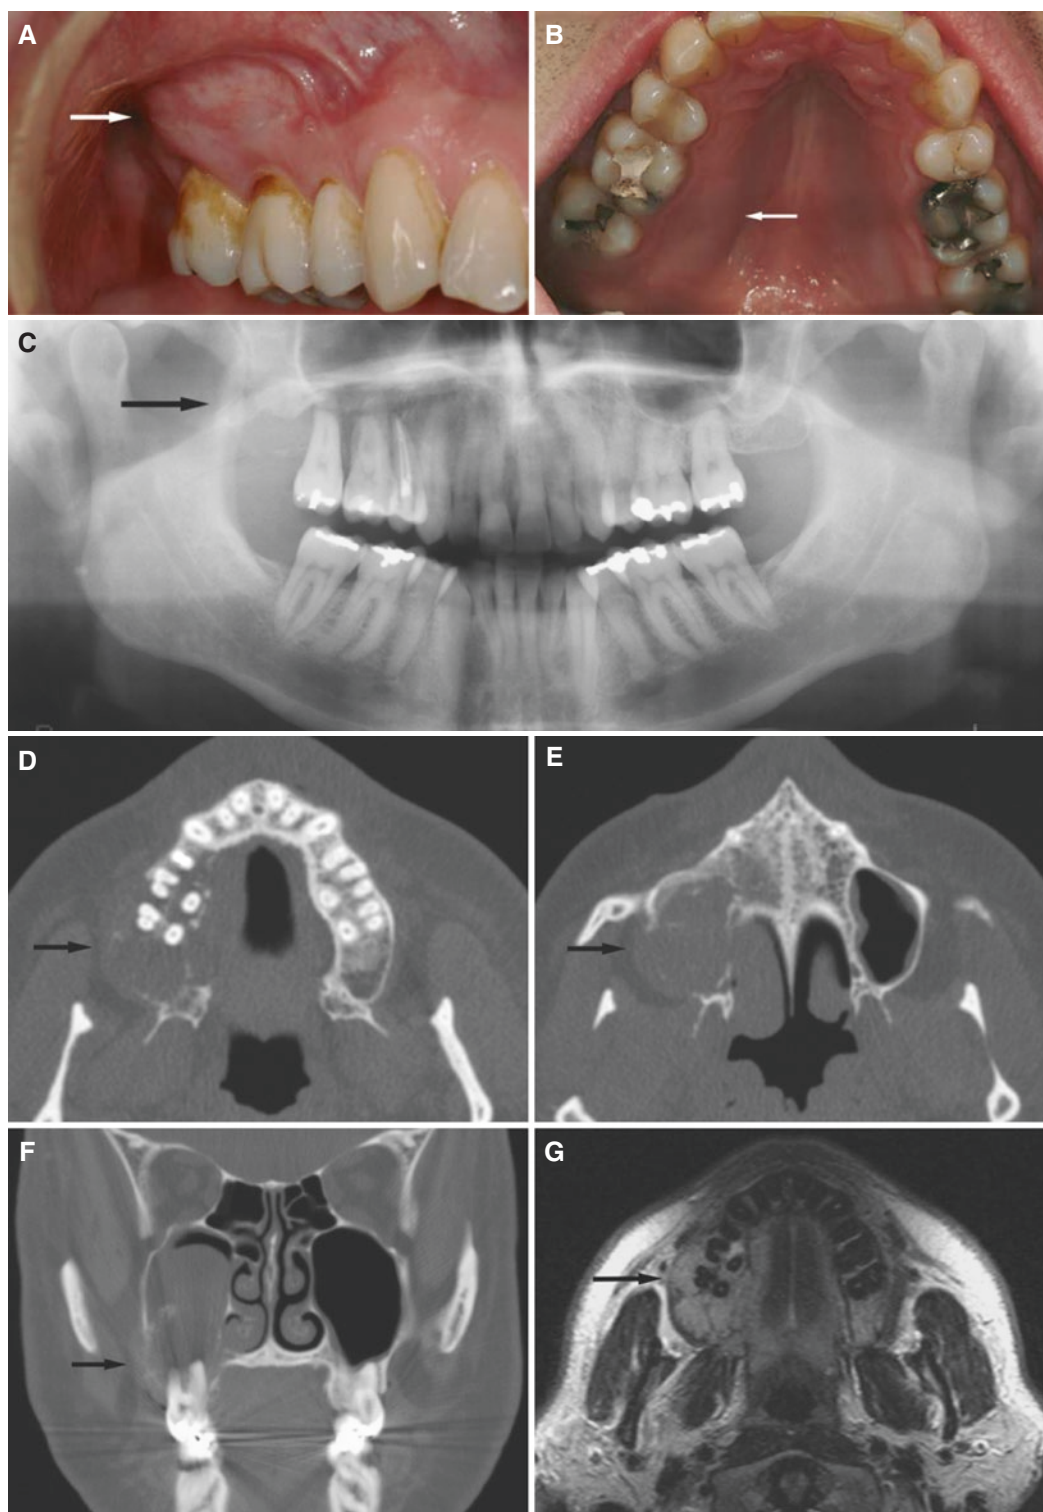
B-cell lymphoma, maxilla; 49-year-old male with slight swelling, painless, but treated for apical periodontitis in the right maxilla. (A) Clinical photograph shows buccal swelling with normal mucosa (arrow). (B) Clinical photograph shows palatal swelling with normal mucosa (arrow). (C) Panoramic view shows diffuse alveolar bone destruction (arrow). (D) Axial CT image shows ill-defined alveolar bone destruction (arrow). (E) Axial CT image shows ill-defined bone destruction of sinus walls (arrow). (F) Coronal CT image shows bone destruction and tumor in maxillary sinus (arrow). (G) Axial
